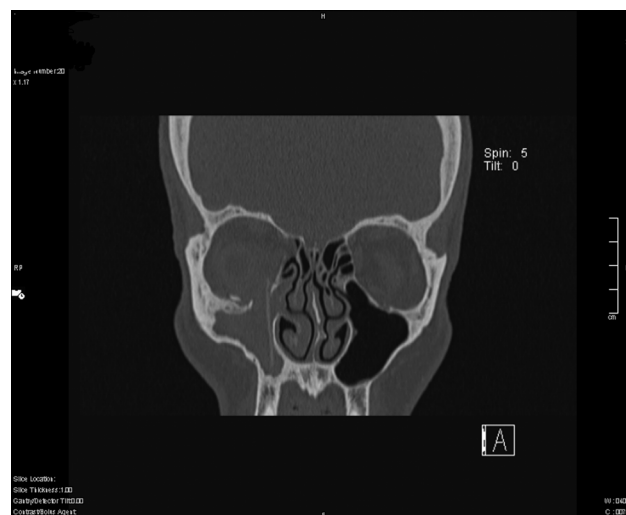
Coronal slice of CT scan demonstrating silastic sheet protruding through the right orbital floor.
